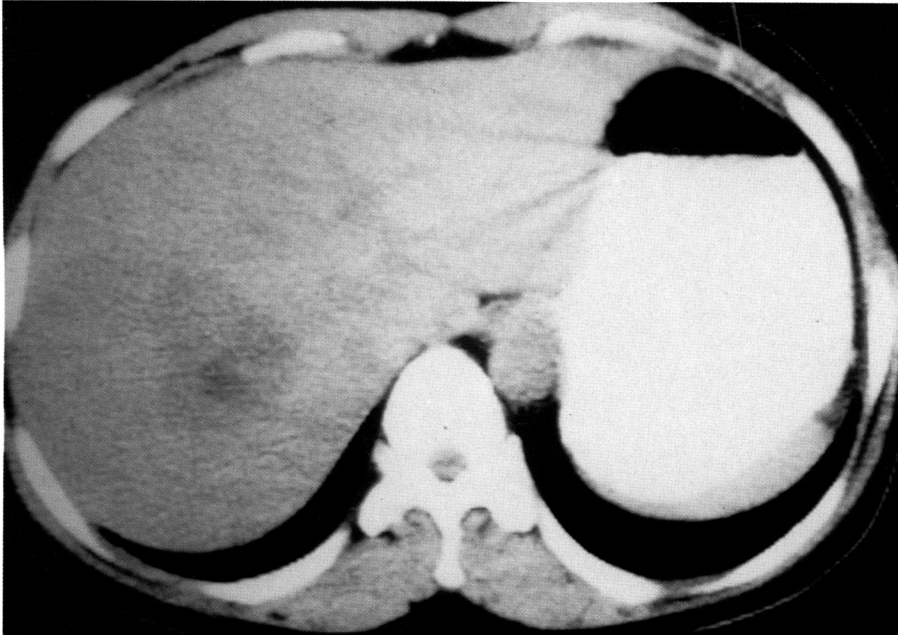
CT scan of the abdomen, disclosing a low density mass at the posterior segment of the liver.
